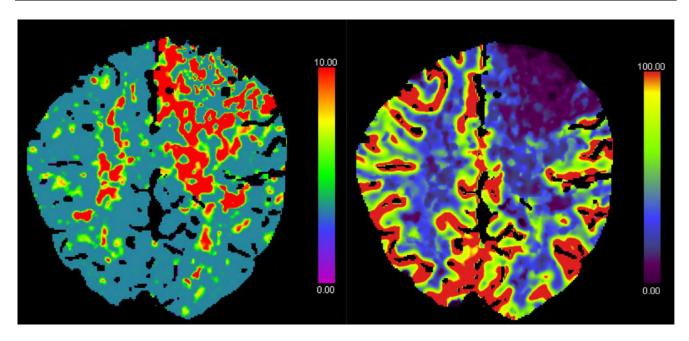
Mean transit time and cerebral blood flow perfusion CT scans showed core infarction involving the basal ganglia, frontal lobe and insula.
